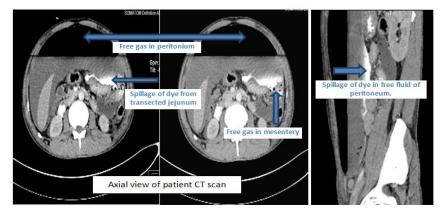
Various view of CT scan of patient
